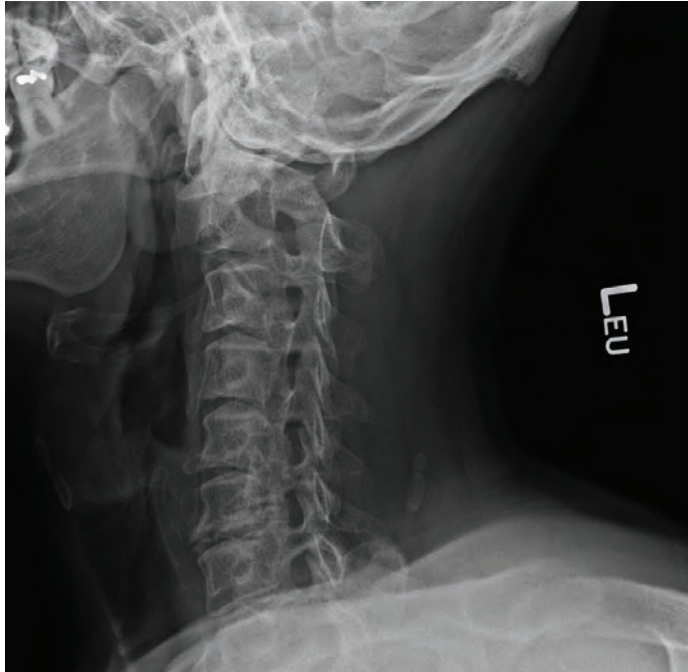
Lateral view of the pre-operative x-ray.
